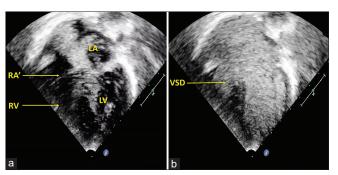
Saline contrast echocardiogram in apical four-chamber view following the injection of agitated saline in the right arm vein shows (a) immediate filling of left-sided atrium (LA) and left ventricle (LV). (b) The right-sided atrium (RA') and right ventricle (RV) fills from flow across atrial septal defect and ventricular septal defect (VSD) respectively
